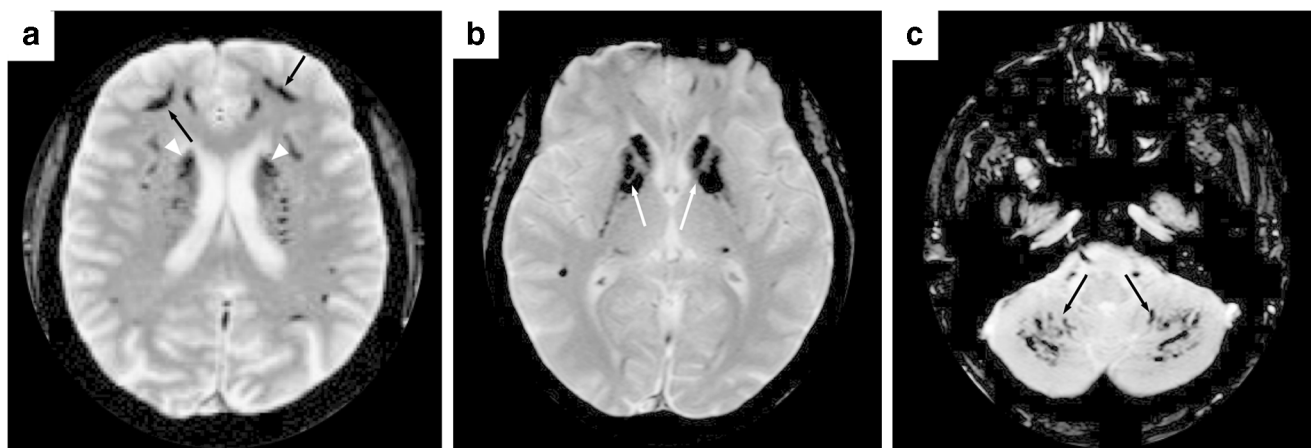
Hyperparathyroidism from chronic kidney disease in a 14-year-old boy. a–c Axial T2*-weighted MRI (a) shows bilateral and symmetrical caudate nuclei (*arrowheads*) and subcortical calcification (*arrows*). In
